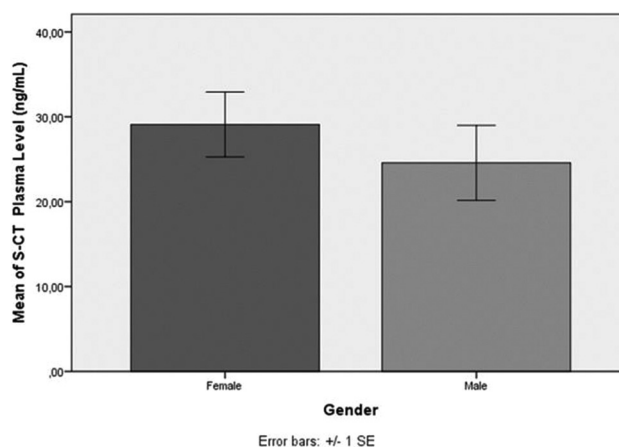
Relationship of Gender and S-CT Plasma Level. Mann–Whitney U-test shows that there is no statistically significant effect of gender difference on S-CT plasma level ( $P > 0.05$ ). Number of samples ( $N_{female}$ : 20,  $N_{male}$ : 10), mean S-CT plasma level (female: 29.10 ng/mL, male: 24.58 ng/mL), standart deviation S-CT plasma level (female: 16.69, male: 13.28)
